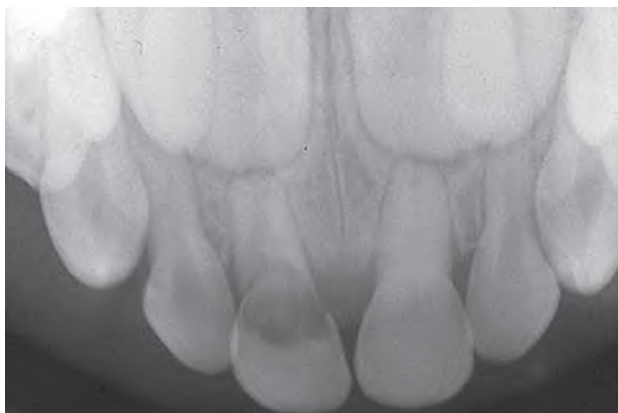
Periapical radiograph of primary maxillary incisor area after trauma in the past. While the primary left central incisor shows obliteration of the pulp cavity, the primary right central incisor shows a large area of internal resorption.
